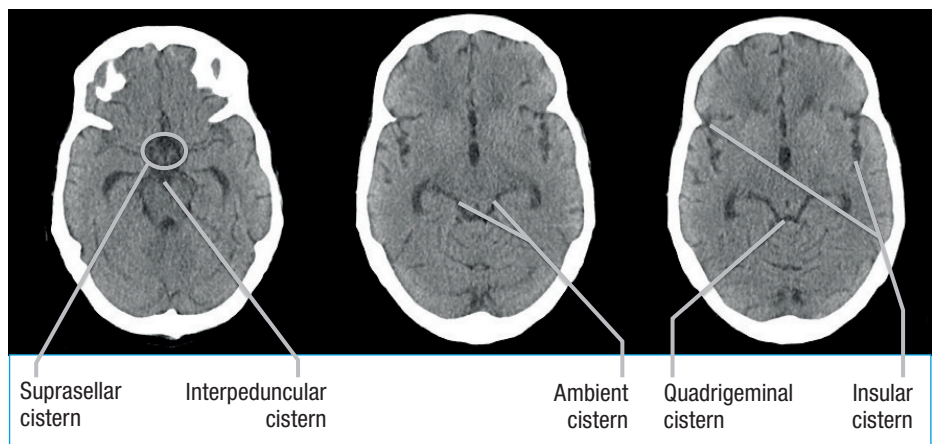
Normal appearances of the major cerebral cisterns. The significance of the major cerebral cisterns is that in cases of subarachnoid haemorrhage these spaces may fill with blood, and in some cases, might be the only sighting of blood on computed tomography. This is the case with the so-called ‘perimesencephalic subarachnoid haemorrhage’ where blood may only be seen within the midbrain cisterns.
